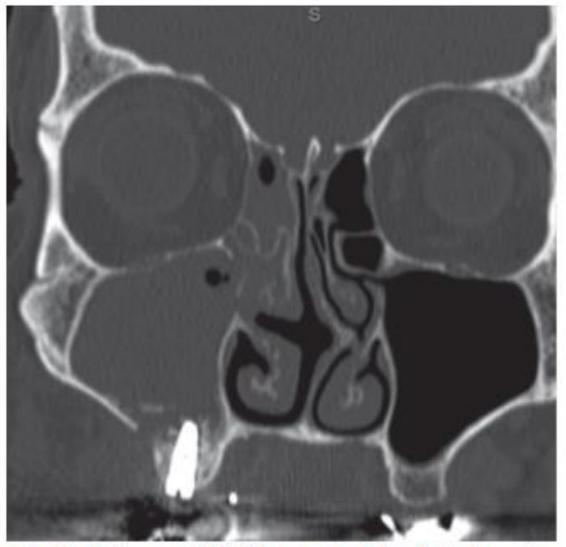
Coronal CBCT image depicting infection after implant placement and sinus graft (SA-3 Immediate).
